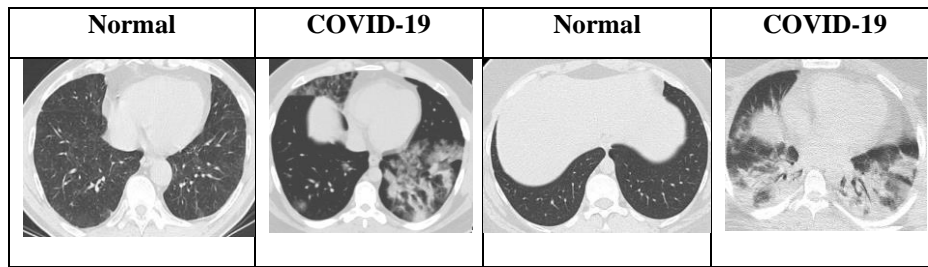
CT images for normal and Covid-19 cases
